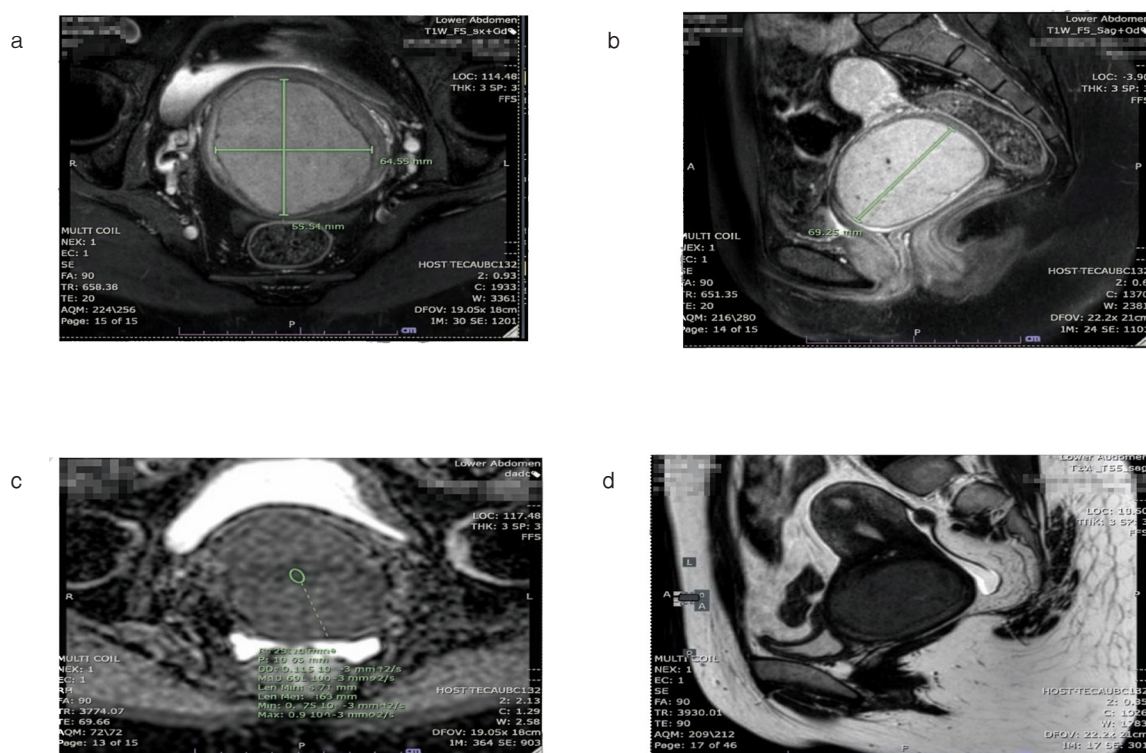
(a) and (b) MRI lower abdomen showed a well-defined homogenous hyposignal T1W/heterogenous hypoposignal T2W mass at the posterior cervical lip, size about 7.0x 6.5x6.9 cm. Hypervascularity is noted with homogenous enhancement. (c) Mild restriction diffusion with low high b-value diffusion-weighted imaging (DWI)/apparent diffusion coefficient (ADC)=0.86x103 mm²/s. (d) No involvement of the upper vagina and parametrium (the hyposignal T2W cervical stroma is about 4 mm). Normal both ovaries. No intraabdominal lymphadenopathy. No hydronephrosis and no hydroureter was seen.
